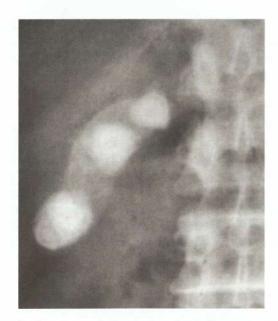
Plain X-ray abdomen showing radio-opaque shadows
